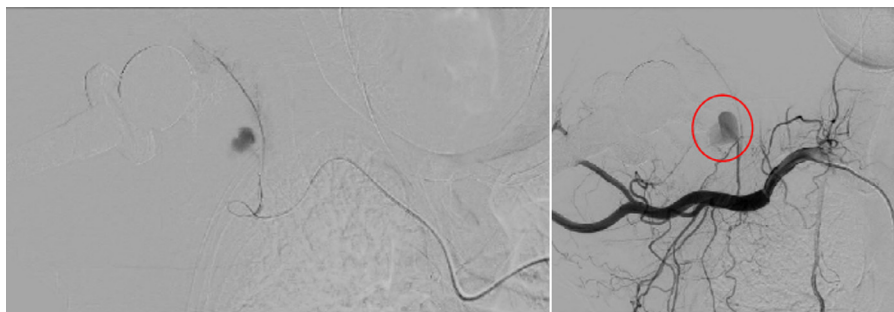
CT angiography showing successful embolization of the 1st branch of the lateral thoracic artery on the second attempt.
